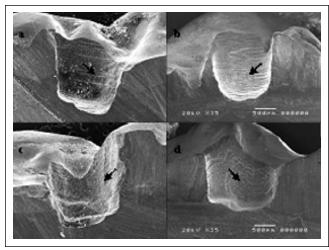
Topography of cavities prepared by high speed (1a, 1b) and ultrasonic abrasion (1c, 1d) instruments in deciduous (1a and 1c) and permanent (1b and 1d) teeth; arrows indicate grooves produced by high speed instrument (1a, 1b) and the apparently "fluffy" an organized in the form of clots aspect left by ultrasonic abrasion instrument (1c and 1d) (SEM-35X).
